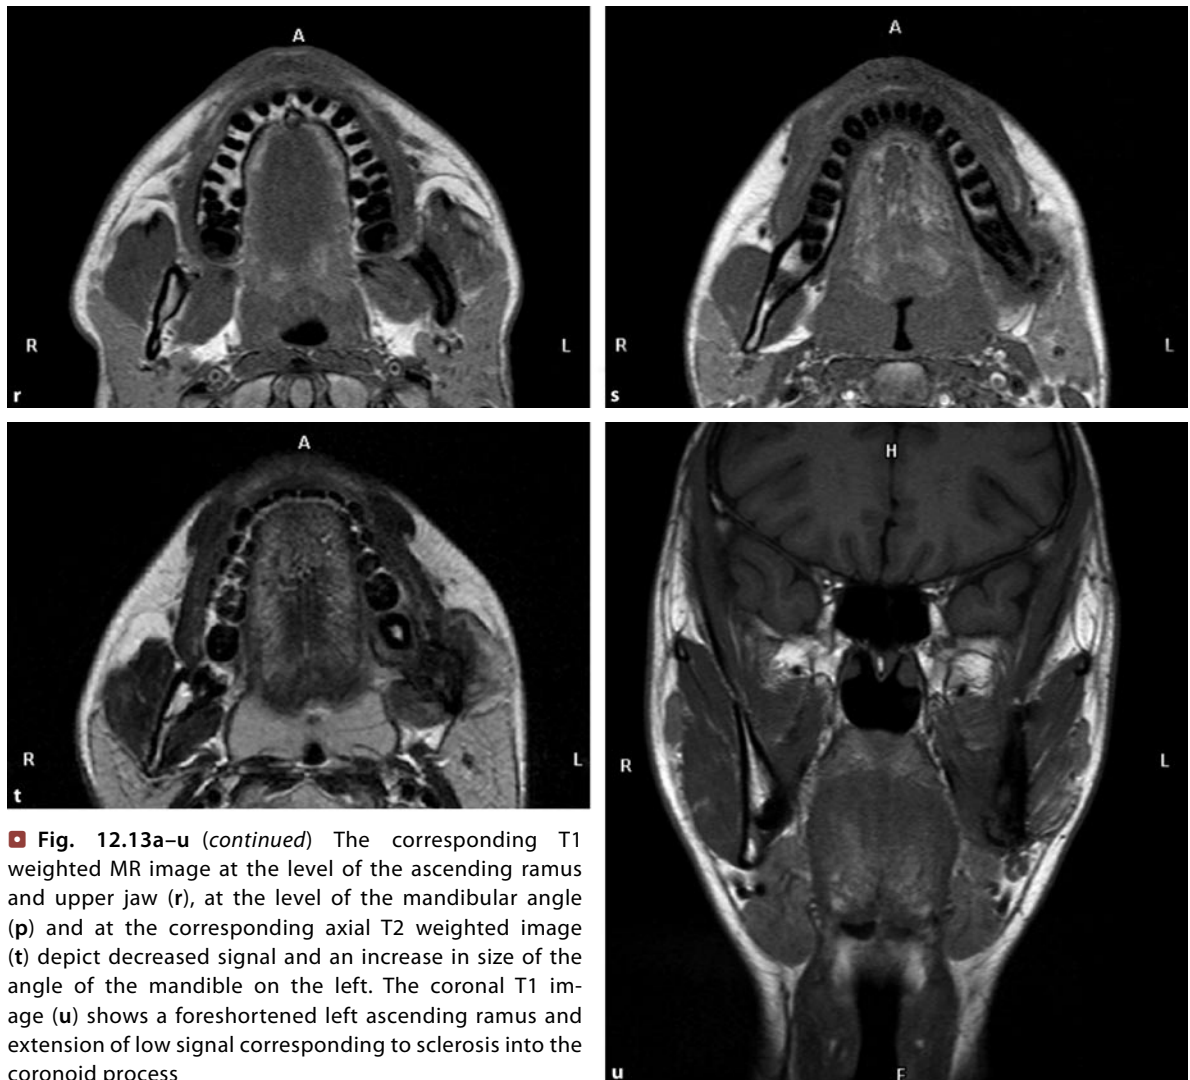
u (continued) o–u The 10-year follow-up CT and MR images: CT scans demonstrate residual increased sclerosis of the left mandibular angle and ascending ramus compared with the unaffected right mandible
